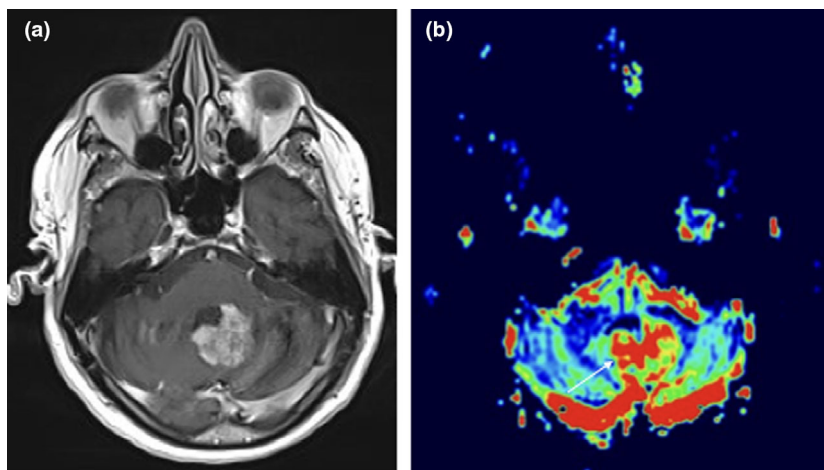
MRI after 5 months: axial T1 contrast-enhanced scan showing cerebellar lesion near the fourth ventricle (a) with high rCBV values (b, white arrow).
